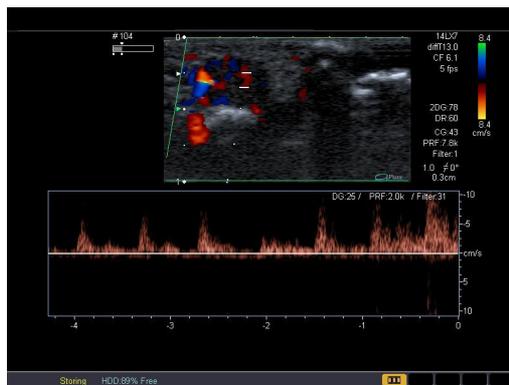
28-year-old woman with an extremely painful solid tissue mass in the fourth finger pulpa. The lesion was very sensitive and painful during the ultrasound. The color Doppler imaging has shown the anechoic lesion with highly internal vascularity.
